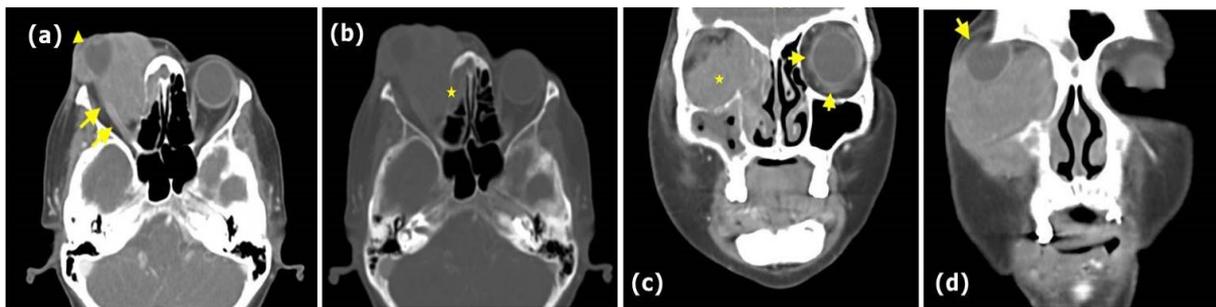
Contrast CT images pre-treatment. (a) Axial image showed enhancing lesion medial to the right globe (yellow arrowhead) occupying the orbit causing proptosis. Extension seen to the anterior ethmoid air cells. No fat plane between the lesion and optic nerve (yellow double arrows). (b) Bone window in axial cut, no calcification within the lesion and the right lamina papyracea (yellow *) is thinned out. (c) Coronal image
